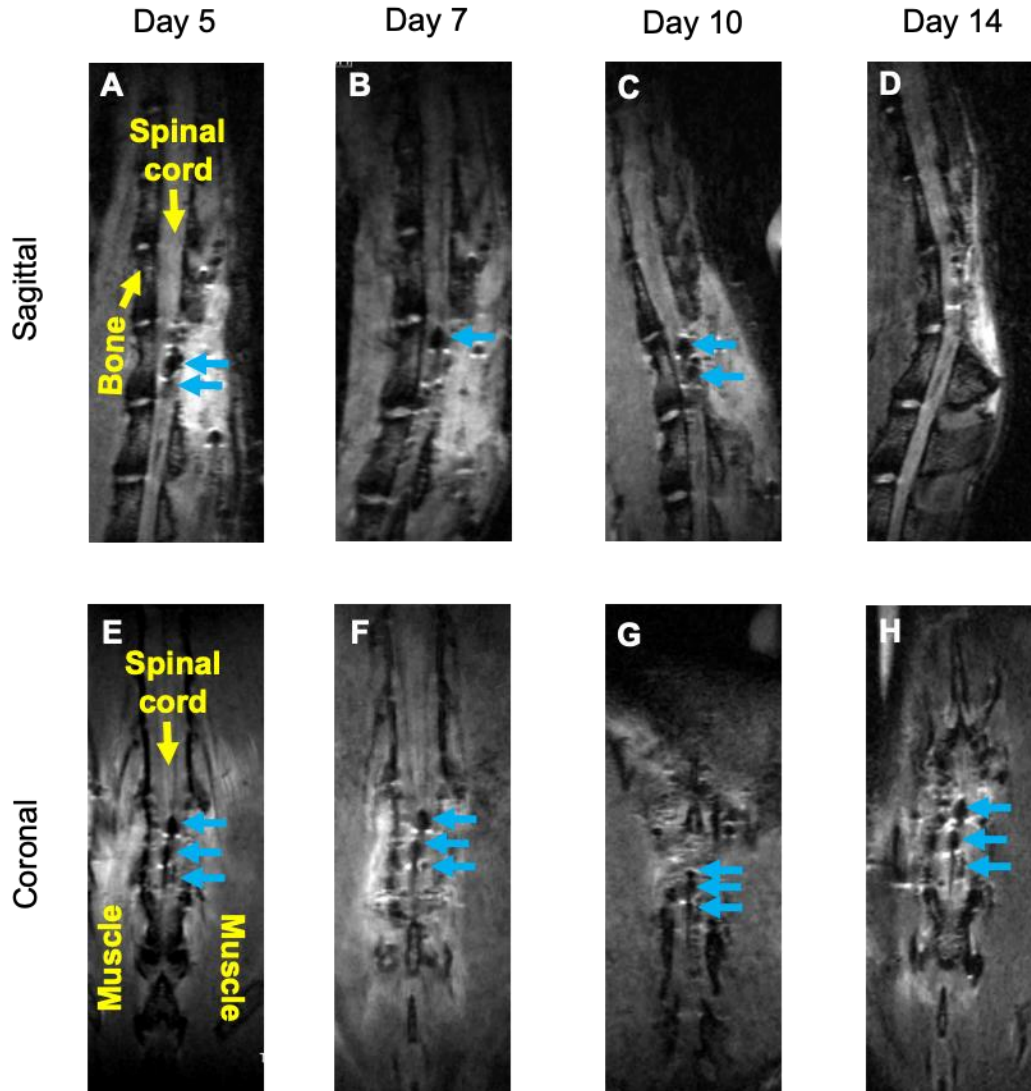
Longitudinal monitoring of PBNC-labeled MSCs MRI *in vivo* – sagittal and coronal views. PBNC-labeled MSCs (5  $\mu$ l at 10k cells/ $\mu$ l) were injected into the spinal cord at three separate locations. Sagittal (top row; A – D) and coronal (bottom row; E – H) Post-operative T2-weighted MR images at 5 (A, E), 7 (B, F), 10 (C, G), and 14 days (D, H). Blue arrows indicate injections of PBNC-labeled MSCs.
